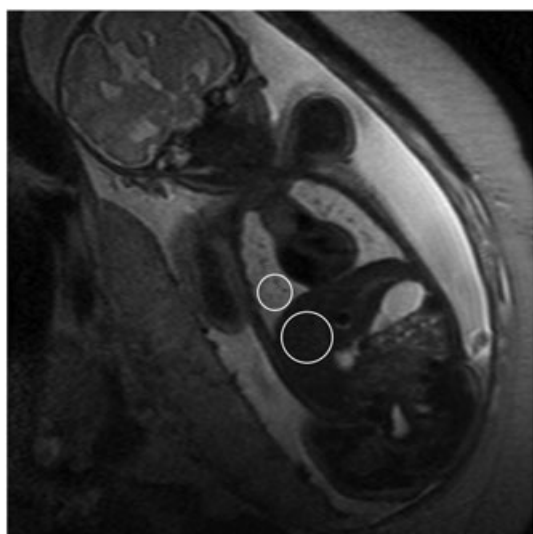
Coronal T2-weighted image of a fetus at 32 gestational weeks. The region of interest for signal intensity measurement in the lung and in the liver are depicted (white circles)
